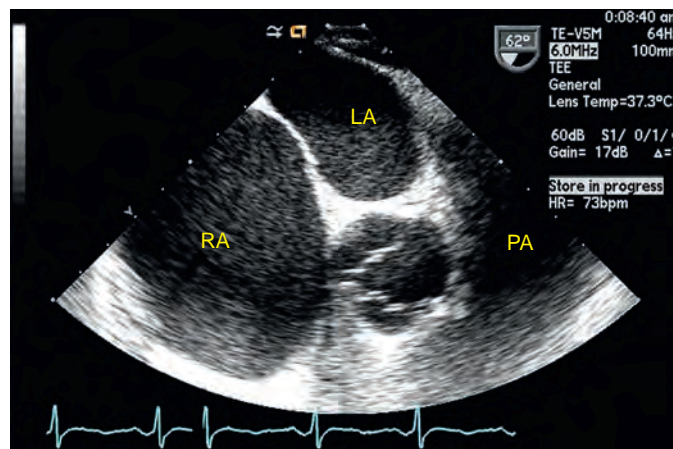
Midesophageal right ventricular inflow-outflow view of patient with severe right atrial enlargement. Note the excessive gain, causing a “washed-out” appearance of myocardial tissue, as well as echogenicity of blood-filled chambers that should typically be echolucent. This artifact can cause the misdiagnosis of spontaneous echocardiographic contrast and the risk of thrombus formation. LA, Left atrium; PA, pulmonary artery; RA, right atrium. (Video clip available online.)
